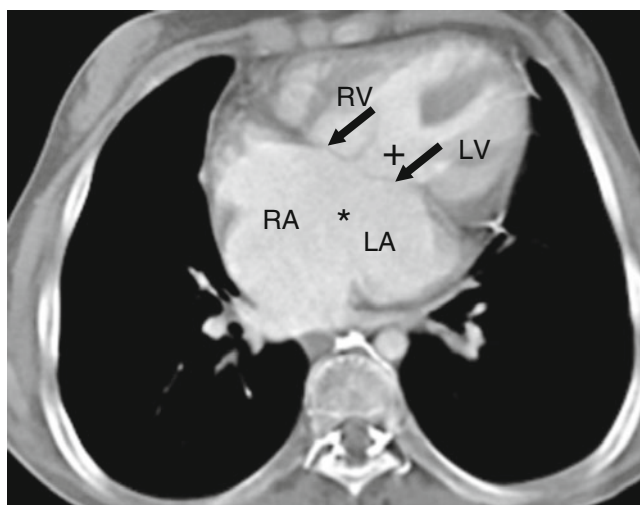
This computed tomographic (CT) image is from a 17-year-old woman with trisomy 21 syndrome who presented with dyspnea and was ultimately found to have a complete atrioventricular canal defect. This axial CT cut at the level of the inferior atrial septum demonstrates an ostium primum atrial septal defect, demonstrated by free flow between the right atrium (RA) and left atrium (LA) denoted by the asterisk and a large inlet ventricular septal defect demonstrated by free flow between the right ventricle (RV) and left ventricle (LV) and marked by the plus sign. There is also a common atrioventricular valve (black arrows)
